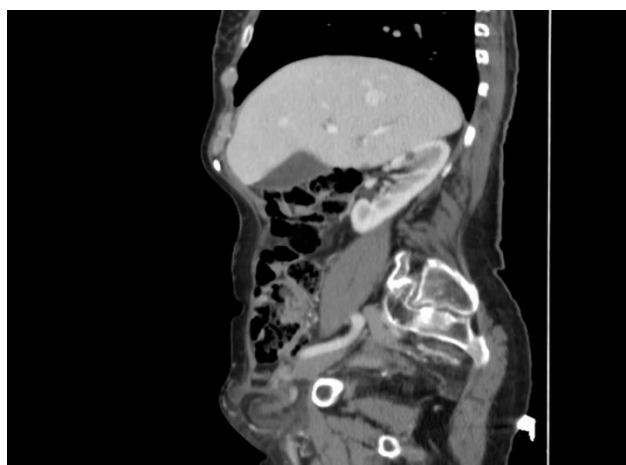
CT showing a right femoral hernia, which contained a small bowel loop with signs of ischemia besides also describing free liquid.
